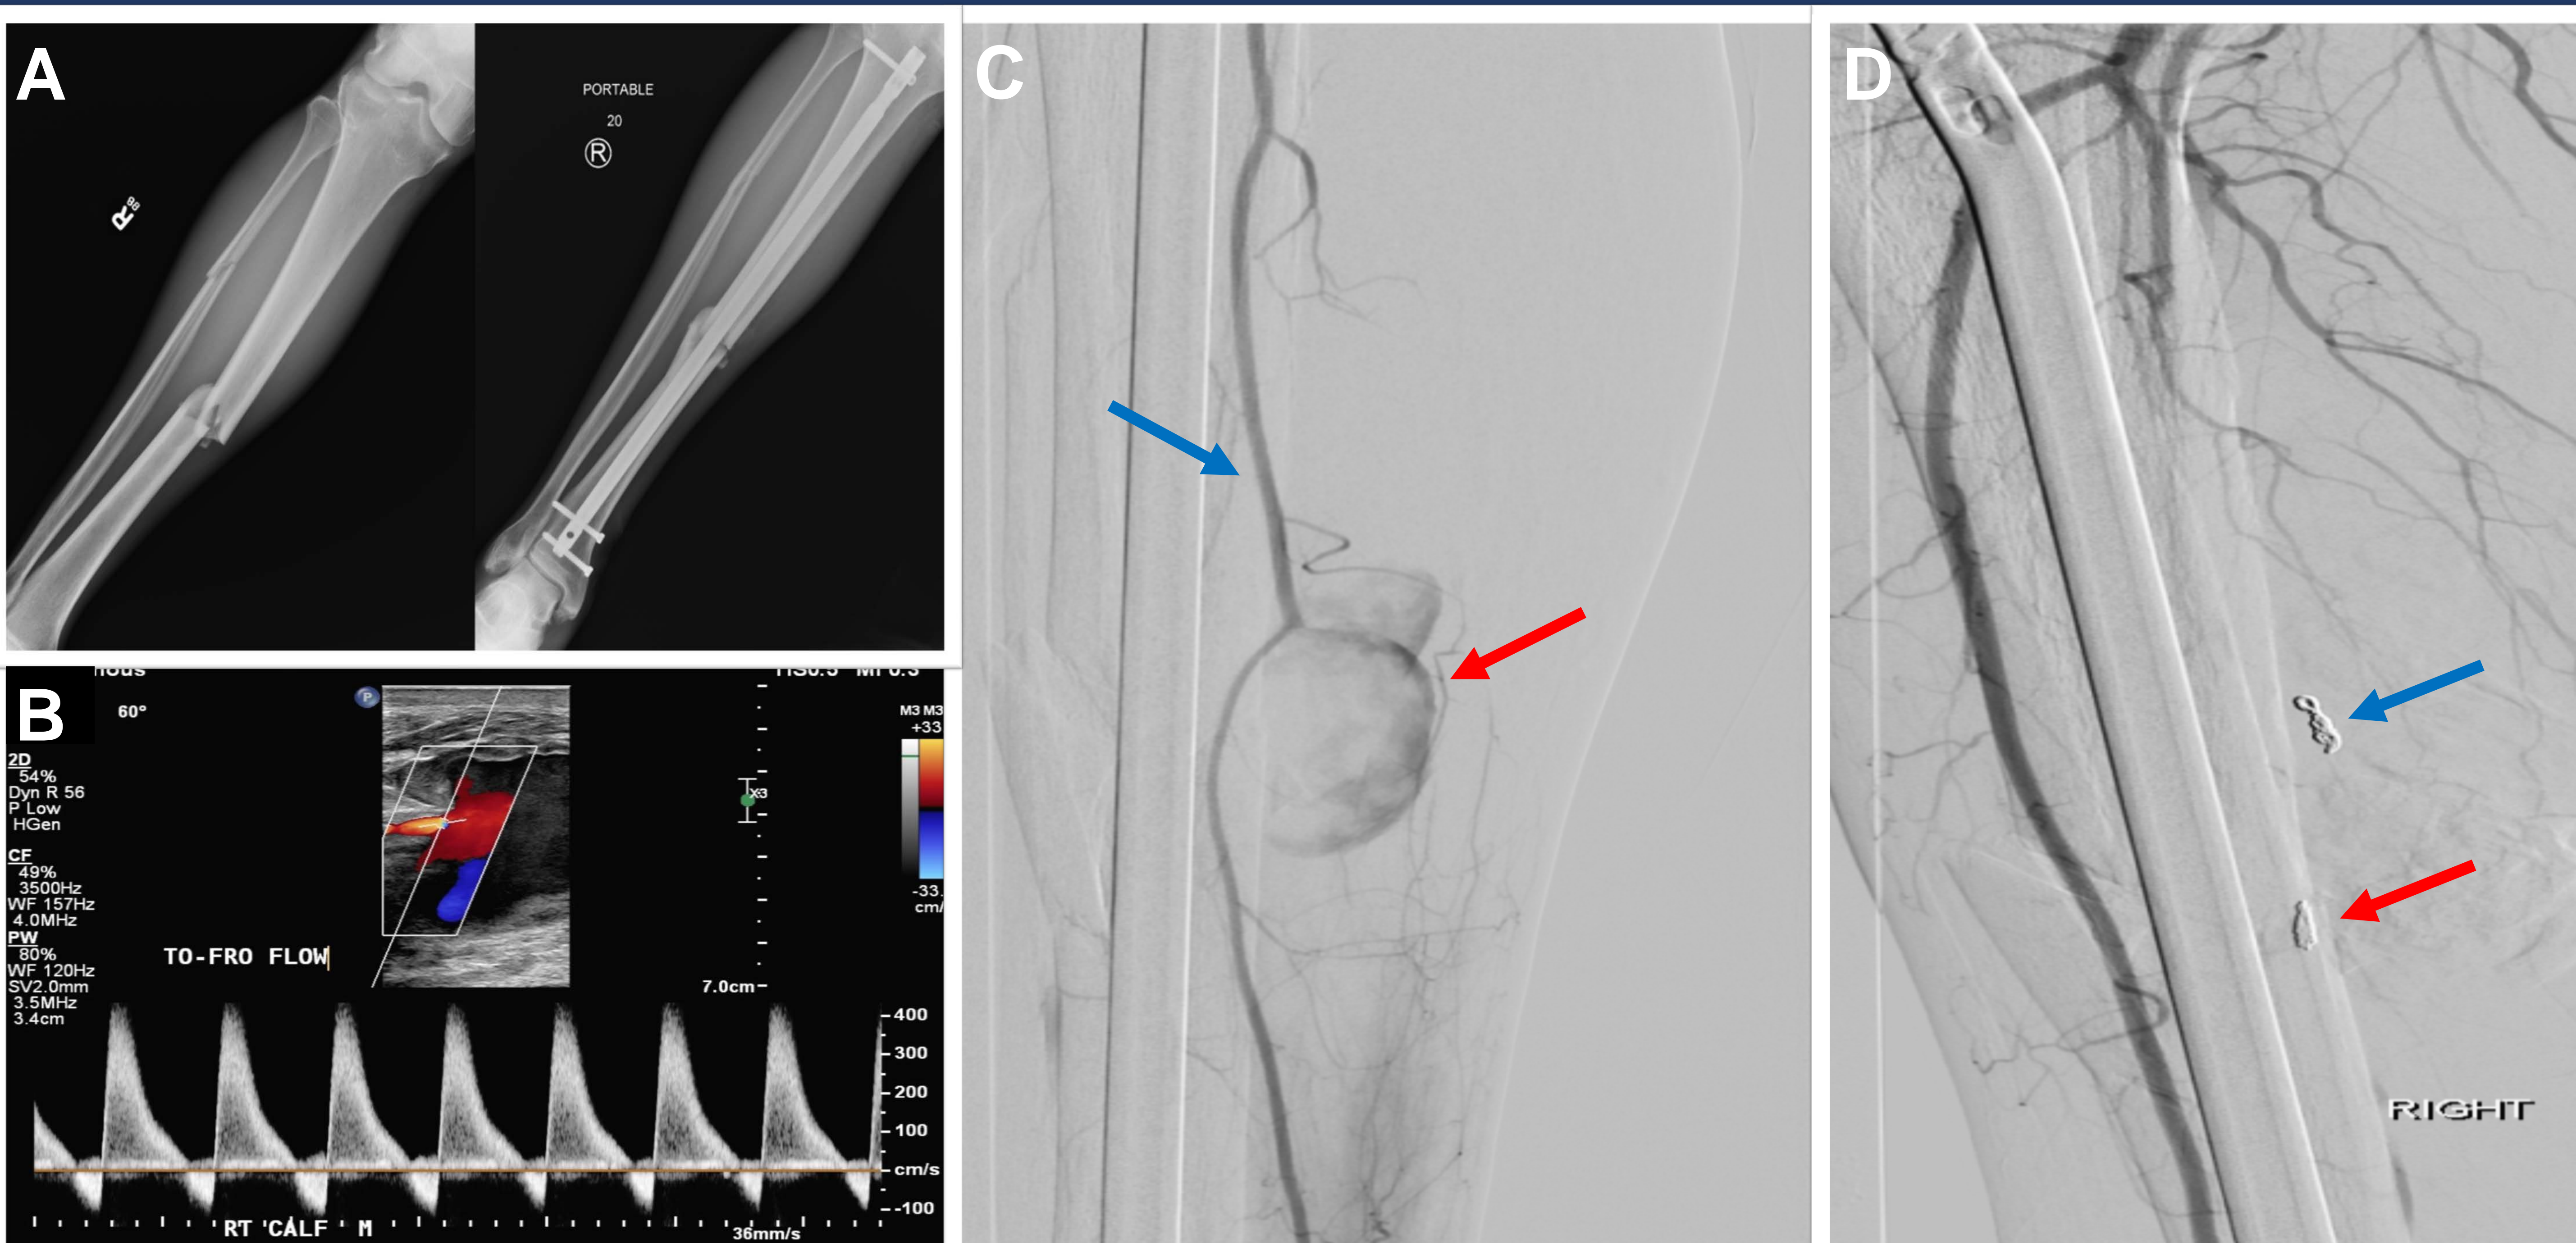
Summary of Case Report 1: A: X-ray of a tibia-fibula fracture from blunt trauma (left) and after completion of intramedullary nail stabilization (right). B: Diagnostic duplex ultrasound of the posterior tibial artery displaying antegrade and retrograde flow waveforms indicative of a pseudoaneurysm. C: Angiogram confirming the presence of a pseudoaneurysm (red arrow, right) secondary to blunt trauma of the posterior tibial artery (blue arrow, left). D: Angiogram displaying an occluded posterior tibial artery after coil embolization proximal (blue arrow) and distal (red arrow) of the damaged artery.
